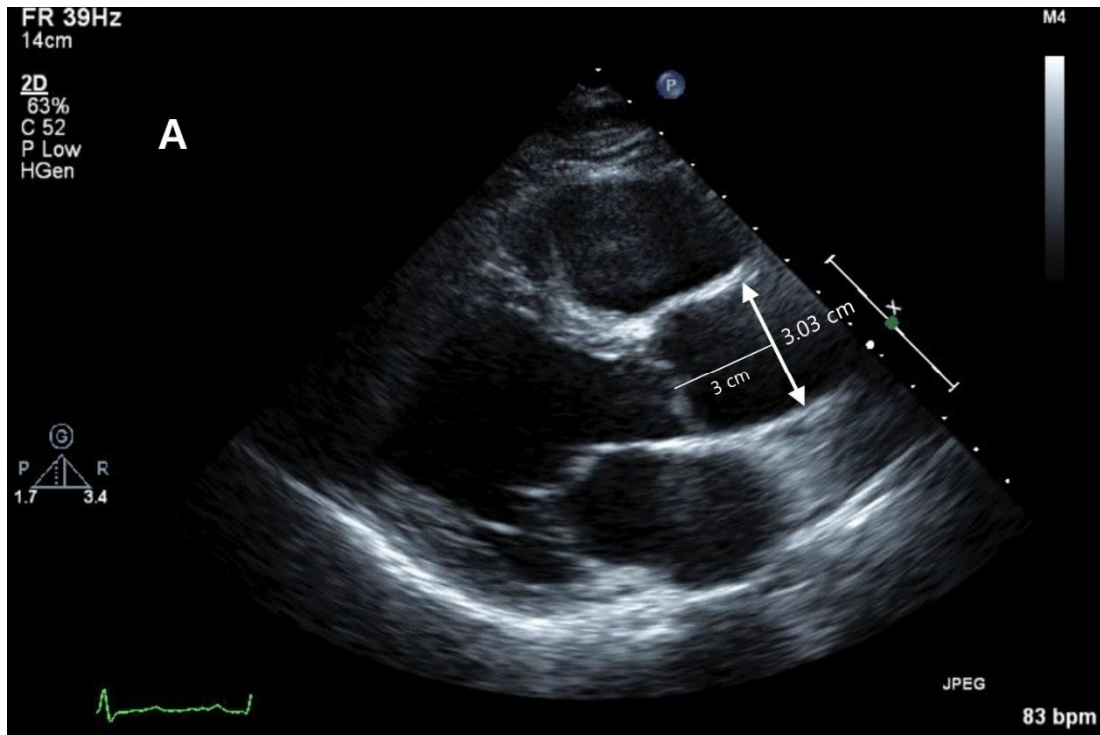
B-mode transthoracic echocardiography on parasternal long-axis view. (A) is end-diastolic period (the peak of QRS complex), and (B) is the time of full opening of the aortic valve. The size of the aortic diameter was measured at a level of 3 cm above the aortic valve (white solid line). Two white arrows indicate internal edges of the aorta.
